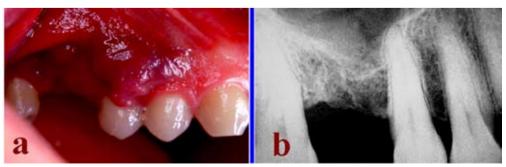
CASE 1: (a.) Four-month-old reddish-bluish lesion on the marginal gingiva at teeth 1.4-1.5 and 1.6. (b) X-ray showed no bone loss at tooth 1.5.
